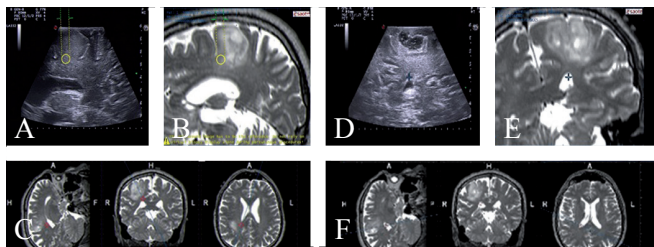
Intraoperative fusion imaging (real-time iUS and pre-operative MRI) findings. Pre-resection sagittal section displaying US findings (A) with a hyper echoic area showed by the pointer tip (cylinder) and corresponding co-planar preoperative MRI findings (B). In D the post-resection US imaging is showed, along with the corresponding pre-operative MRI (E), providing further orientation and help in interpreting the imaging. C and F shows the probe position in the three traditional orthogonal planes.
